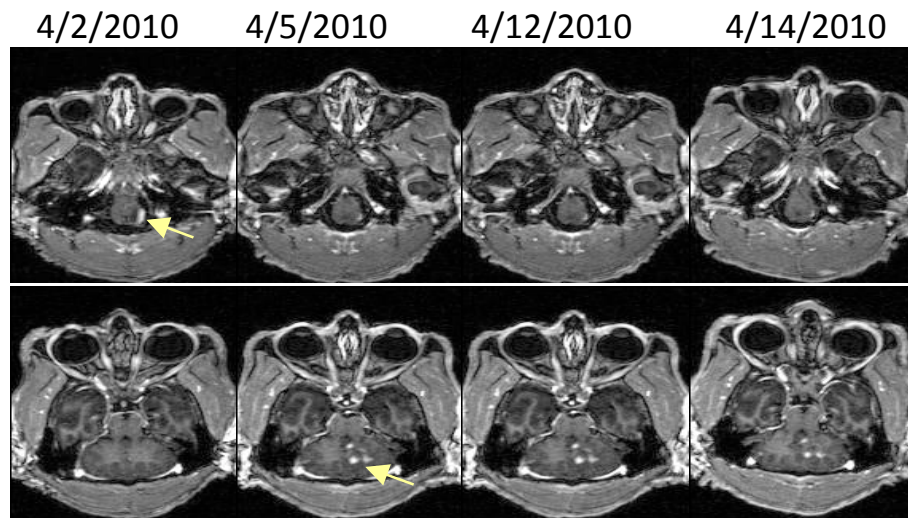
Time series showing post-contrast T₁-weighted images from an 11 y M presenting with left-head tilt, ataxia, and balance problems on 3/31/2010. Upper cord involvement is clearly visualized (see arrow) on the 4/2/2010 top image that partially resolves over a two week period perhaps the result of corticosteroid treatment (145 mg hydrocortison i.v. followed by oral prednisone). Cerebellar post-contrast T₁-weighted hyperintensities became apparent on 4/5/2010 (arrow) and persisted through 4/14/2010. MRI findings are consistent with acute JME.
